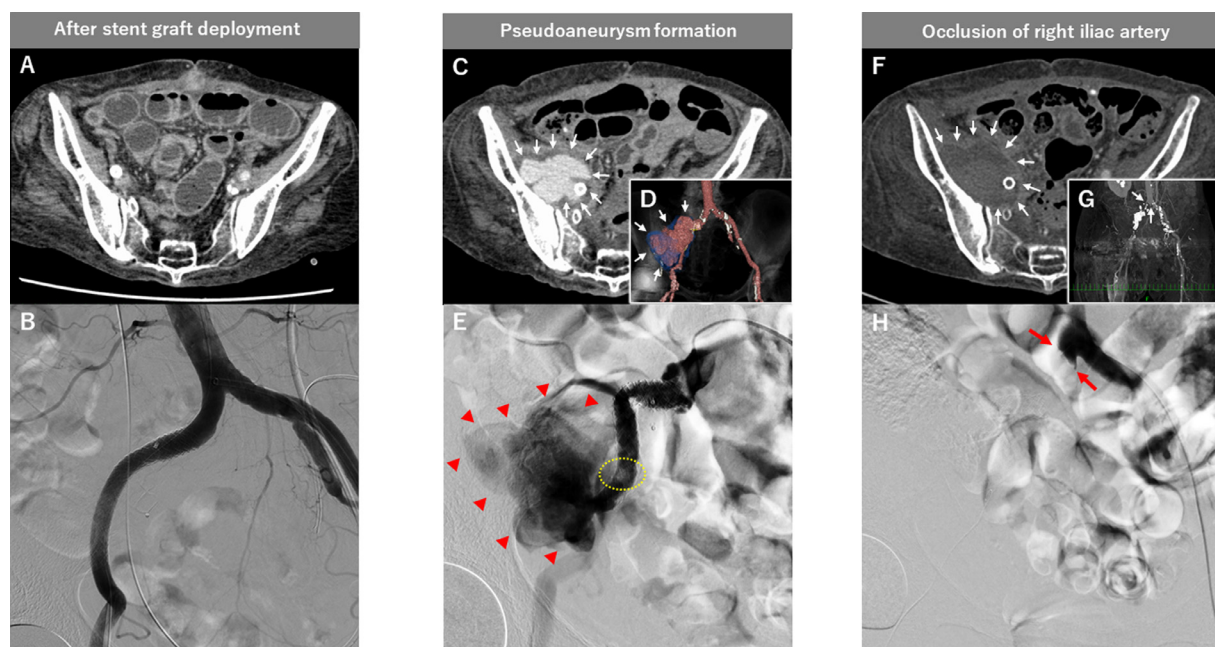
CT scan and angiography findings (A) CT findings after stent graft implantation, (B) Angiography findings after stent graft implantation, (C) CT scan showing a huge pseudoaneurysm formation (white arrow) at the right external iliac artery, (D) CT angiography (coronal plane) showing a huge pseudoaneurysm formation (white arrow) at the right external iliac artery, (E) Angiography showing pseudoaneurysm formation (red arrowhead) and floating thrombus (yellow dotted oval), (F) CT scan showing no contrast into the pseudoaneurysm (white arrow), and (G) occlusion of the right iliac artery from the ostium of the right common iliac artery to the right common femoral artery (white arrow), (H) Angiography showing occlusion of the right iliac artery from the ostium of the right common iliac artery (red arrow), CT, computed tomography. (Color version of figure is available online.)
